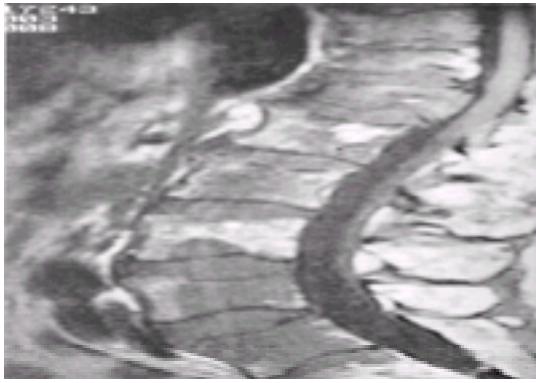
Magnetic resonance image (MRI) showing spinal cord compression from metastatic prostate cancer. This is an emergency that requires prompt treatment with corticosteroids and radiation.
